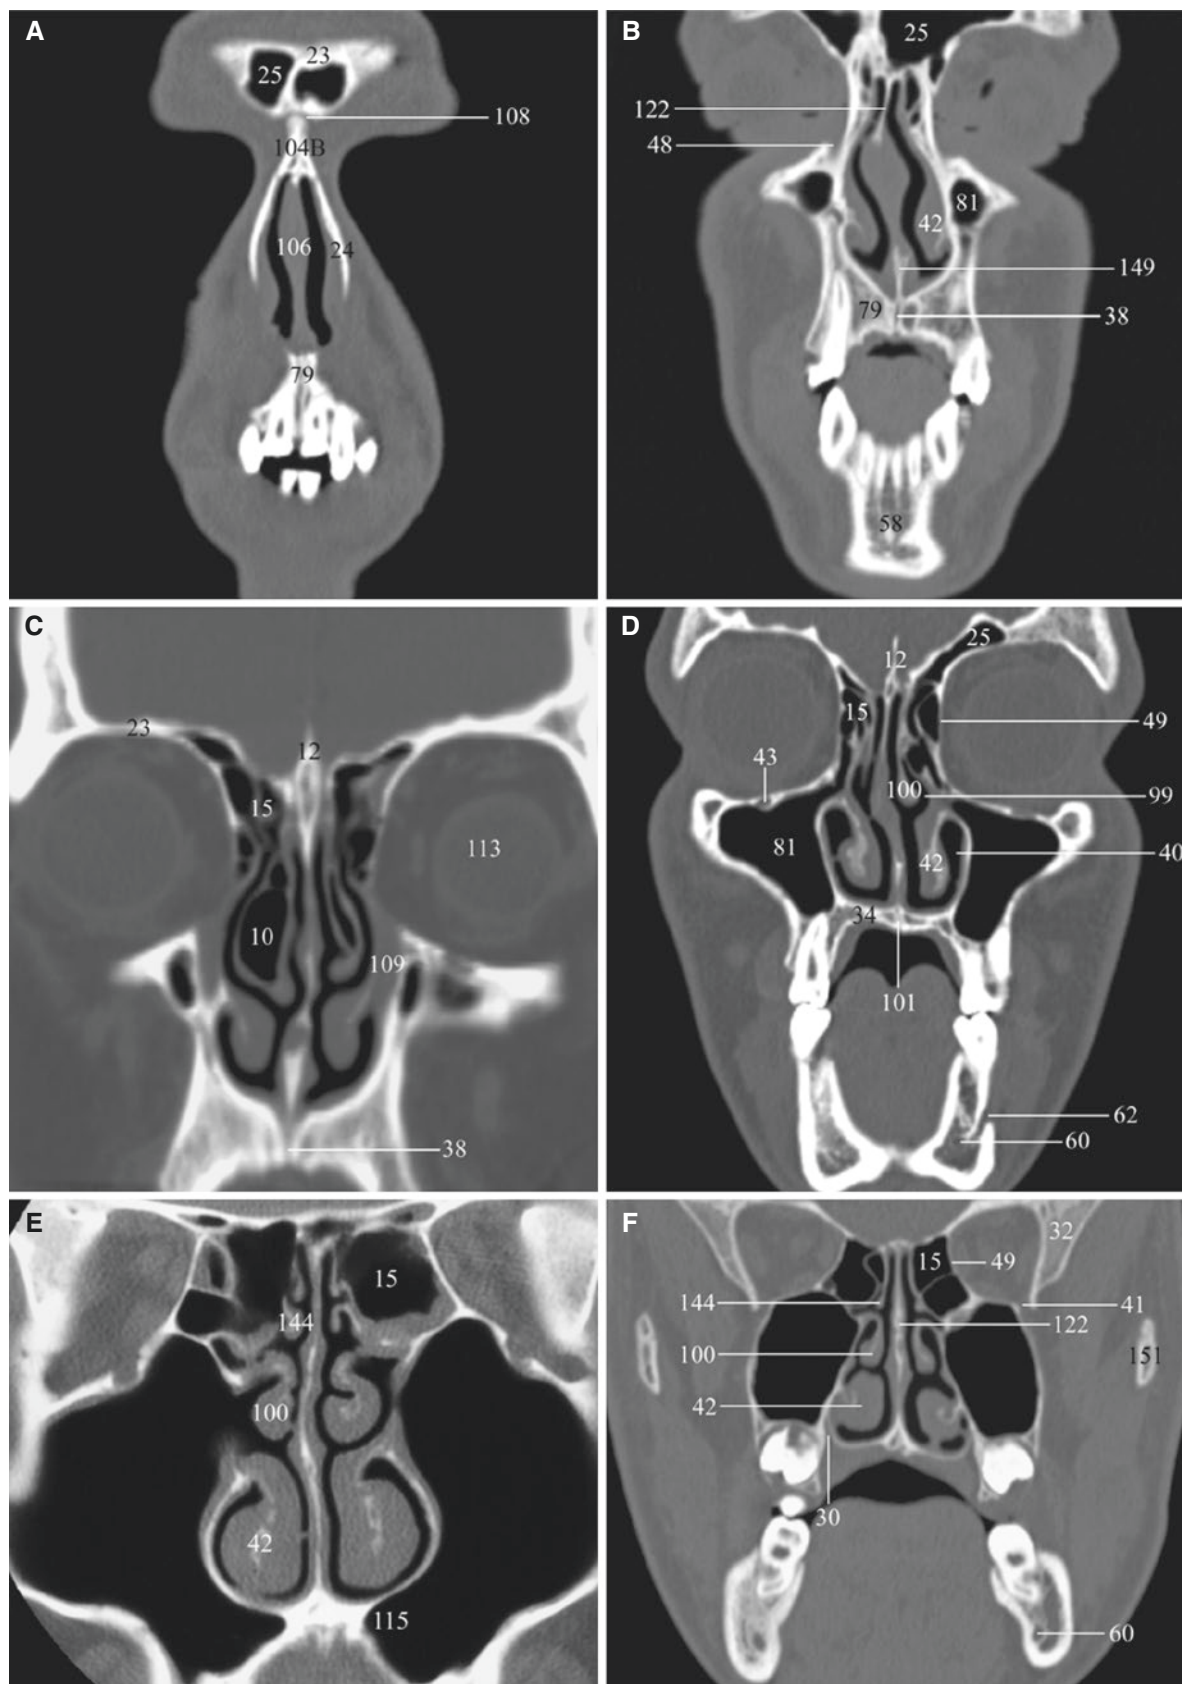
Normal bone anatomy of face; coronal CT images from anterior (A) to posterior (J)
